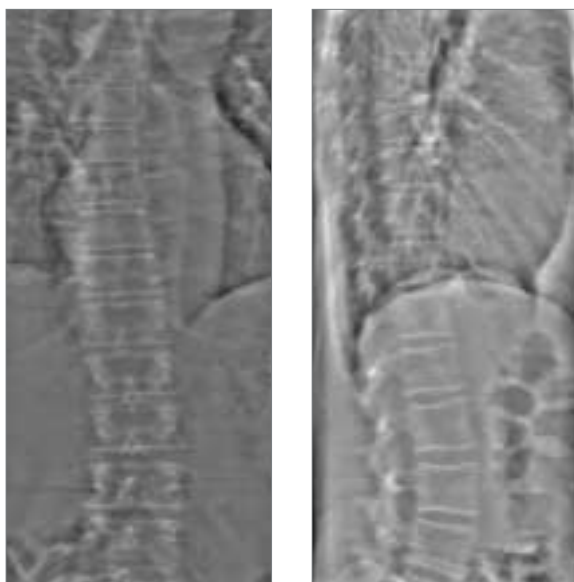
The single-energy, breath-hold imaging technique provides high-quality images for vertebral assessment. Standard radiographic protocols include AP (left) and lateral (right) spine images.
